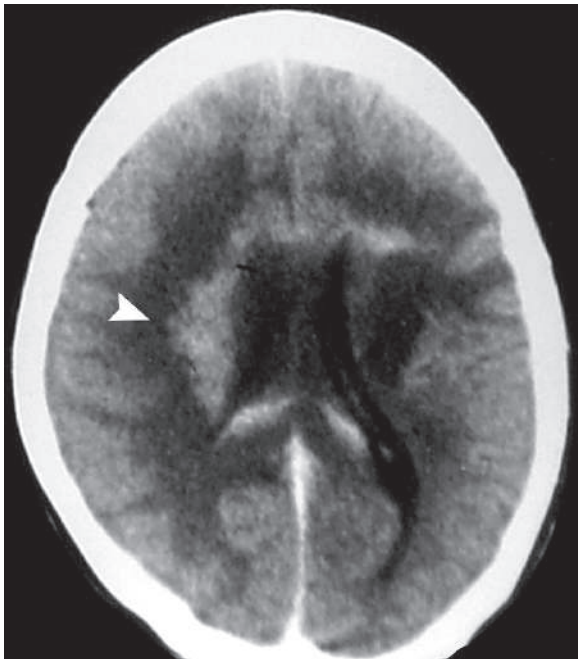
Axial postcontrast brain CT of a patient with CNS lymphoma shows right-sided homogeneously-enhanced subependymal mass (*arrowhead*)
